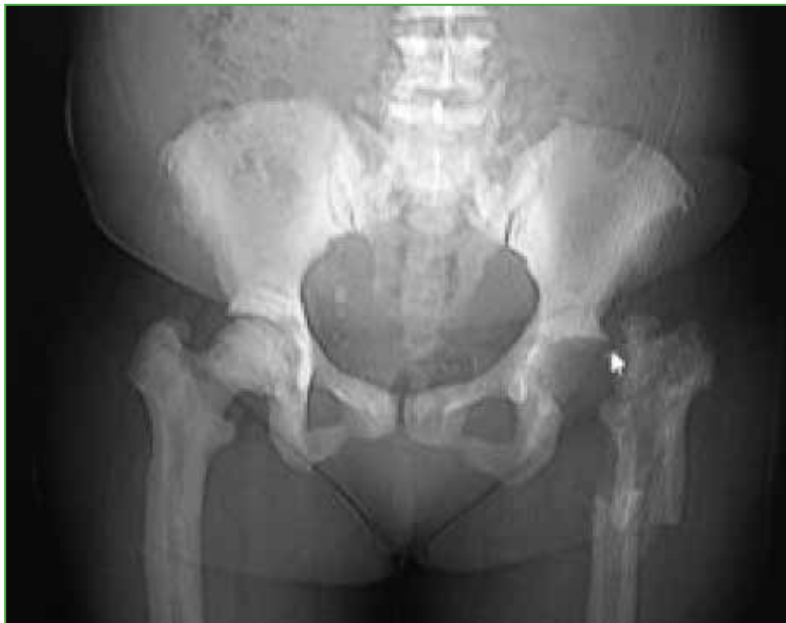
Postoperative control radiograph of removal of osteosynthesis material plus interposition arthroplasty with resection of the femoral head.
